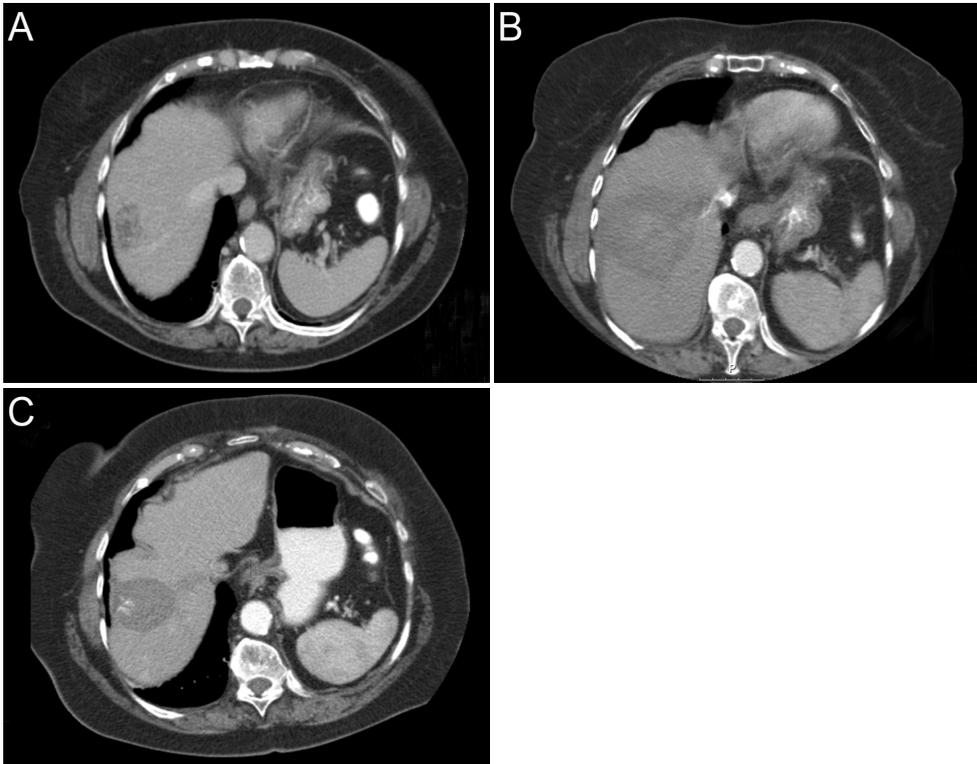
(A) CT scan of a 80-year-old woman demonstrating a hepatic metastasis from colorectal cancer in liver segment VIII with a diameter of 5.3 cm, (B) CT scan one week post LITT demonstrating complete ablation with a coagulation lesion of 6.8 cm in diameter, (C) CT scan 15 months after LITT treatment showing a scar lesion of 4.1 cm in diameter.
